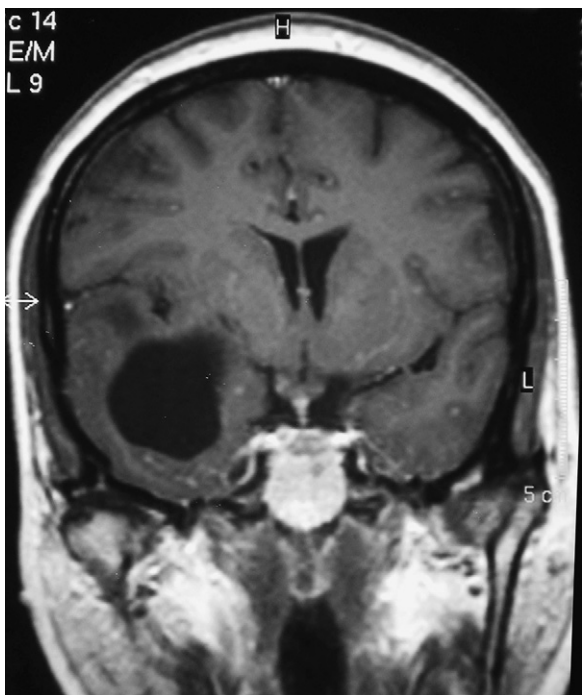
Coronal MRI (T1 sequence with gadolinium). Pituitary stalk involvement.
